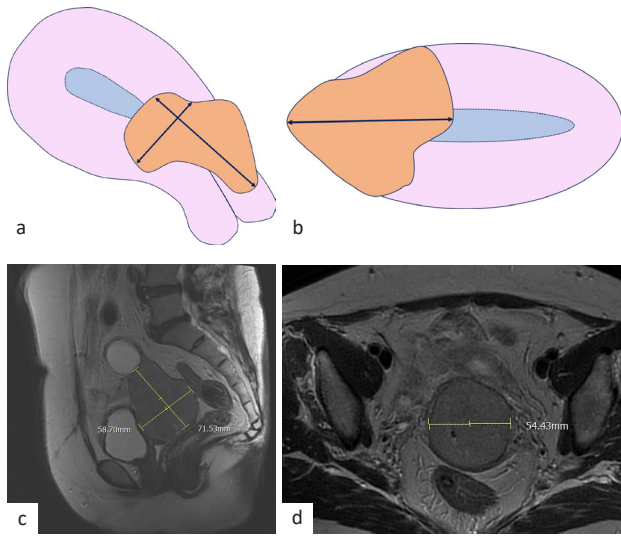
Example of measurement in 35-year-old female with cervical cancer. Measurement scheme of cervical tumor in sagittal (a) and axial (b) plane; correlate with measurement of cervical tumor on T2WI MRI sequence in sagittal (c) and axial (d) plane. MRI=magnetic resonance imaging; T2WI=T2-weighted imaging
